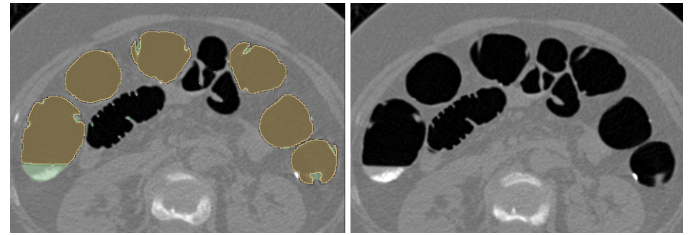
On the left, a segmentation of the colon is shown by a mask overlay highlighting air pockets in yellow and liquid pockets in green. This was achieved using our method. The image on the right is the unprocessed CT scan, where the heterogeneity of the contrast within the liquid pockets is more evident.
